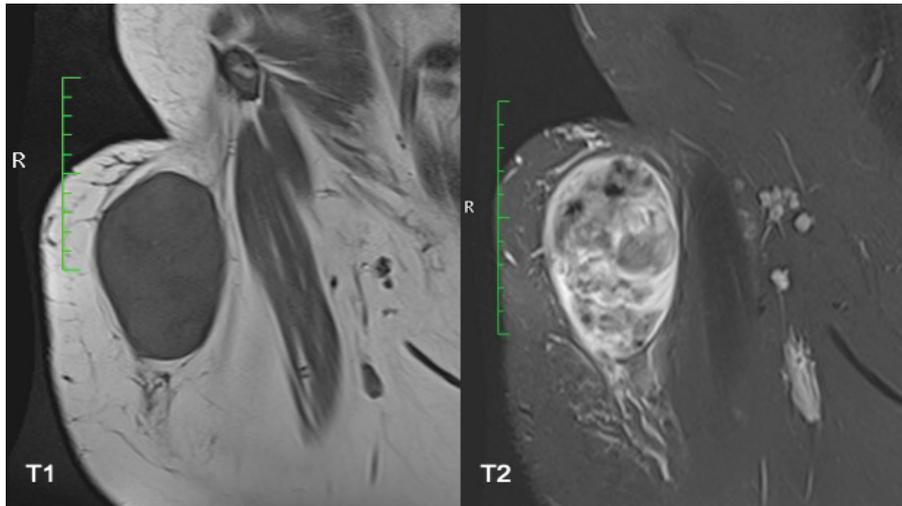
MRI of the right thigh of a 14-year-old, with coronal view in T1 weighted sequence and T2 with FS weighted sequence, showing a well-defined, extra-articular, mass of the thigh, hypointense in the T1 sequence, with a “triple sign” in the T2 image, leading to diagnosis of synovial sarcoma.
